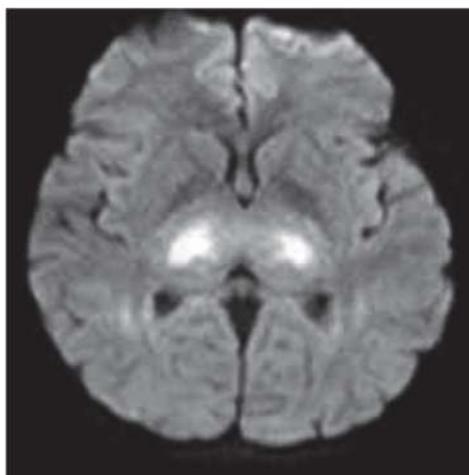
Axial DWI image showing diffusion restriction in bilateral thalami.
